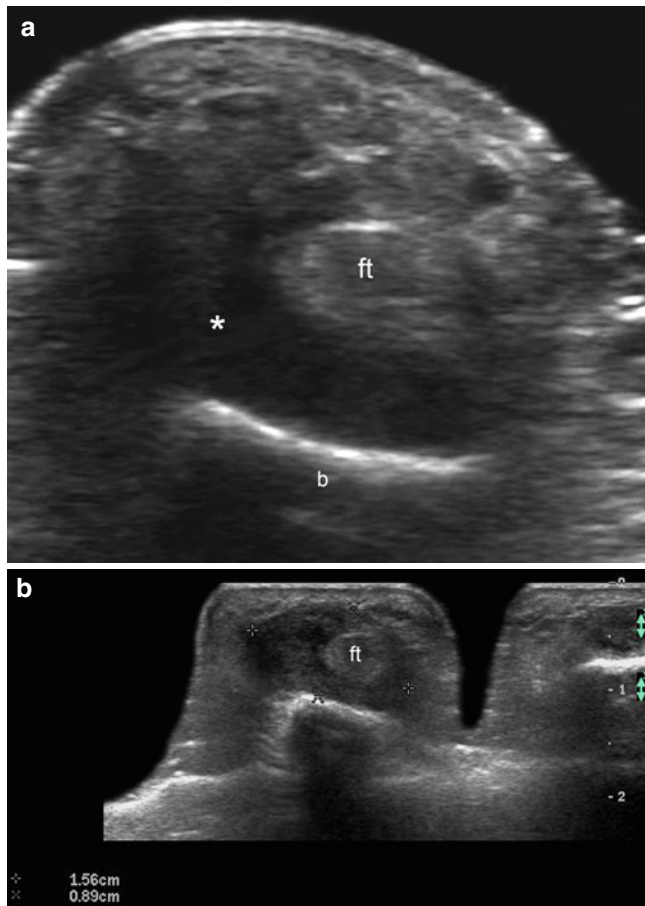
(a, b) Giant cell tumor of the tendon sheath. (a, b) Grey scale ultrasound images (transverse views; b: zoomed image; c: extended image) show a 1.56 cm (wide)×0.89 cm (deep) hypoechoic solid structure (*, between markers) that embraces the flexor digitorum tendons of the right index finger. *Abbreviation:* b bony margin of the proximal phalanx
